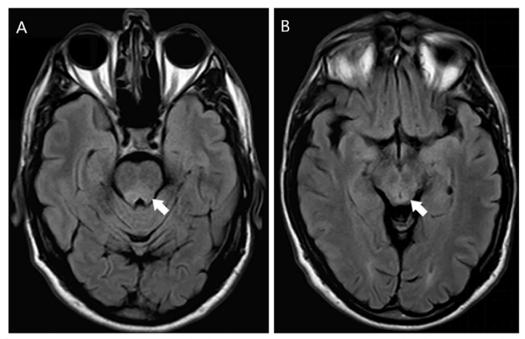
Axial fluid attenuation inversion recovery T2-weighted magnetic resonance imaging sequences. A Slight hyperintensity in the posterior portion of the pons (white arrow). B Slight hyperintensity in the midbrain tegmentum (white arrow)
